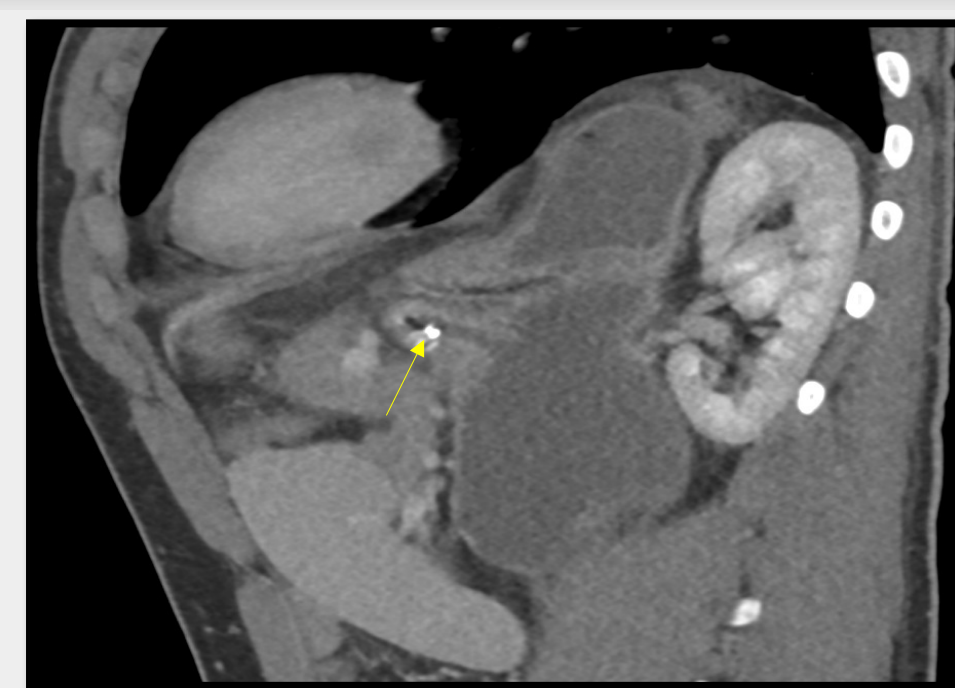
Sagittal CT reconstruction demonstrating inferior displacement of the nasogastric tube (arrow) within the gastric cardia relative to the superiorly displaced antrum and pylorus.
